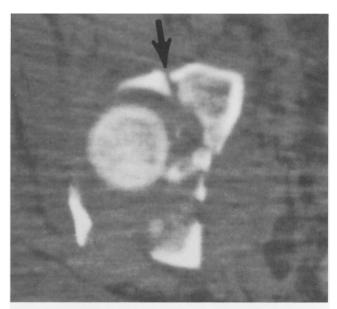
The CT cut near the dome shows an anterior fracture line (black arrow) and suggests a general anterior to posterior fracture configuration, indicating a transverse pattern.
